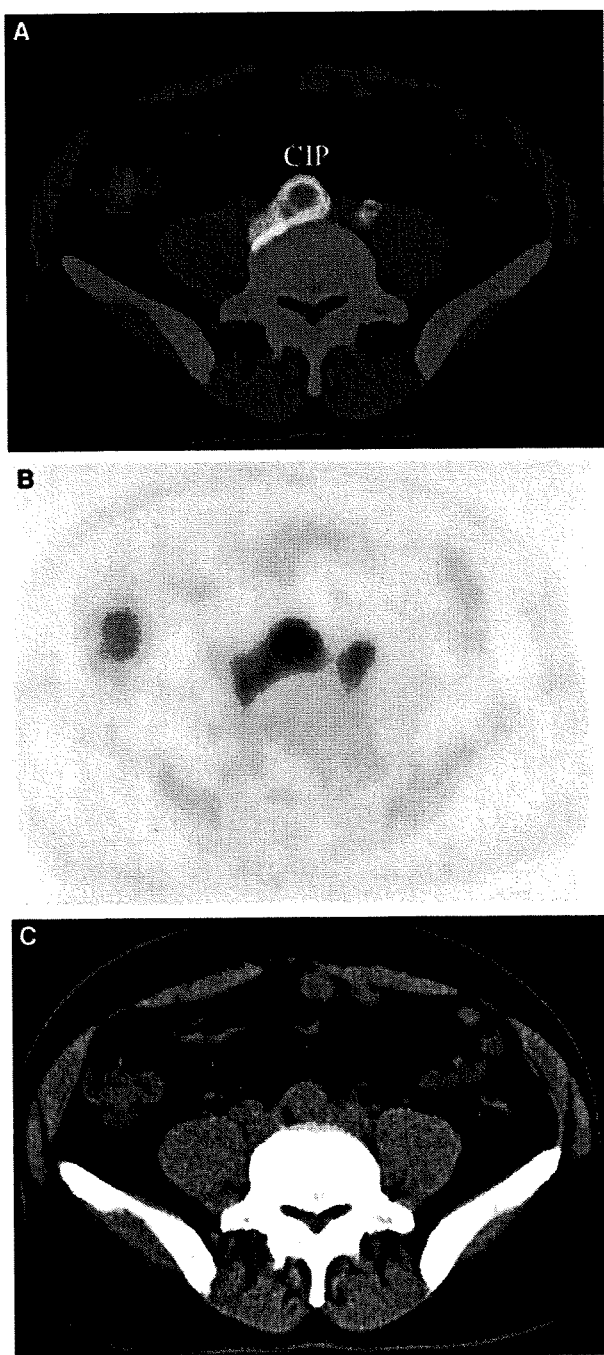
Axial noncontrast PET/CT image (A), PET (B), and CT (C) shows enlarged common iliac promontory (CIP) lymph nodes with increased uptake in patient with follicular lymphoma.
